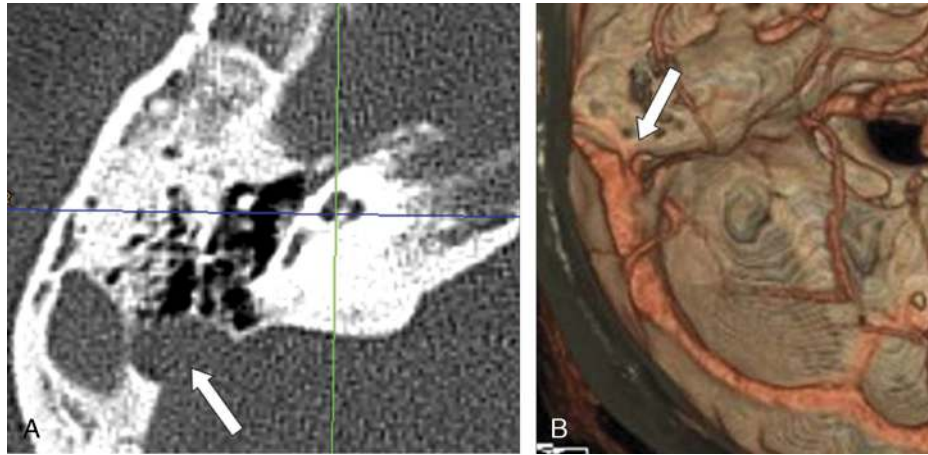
A, Axial angio-CT scans: arrow shows atypical route of the sigmoid sinus and emissary veins. B, Three-dimensional reconstruction of the vessel malformations.
